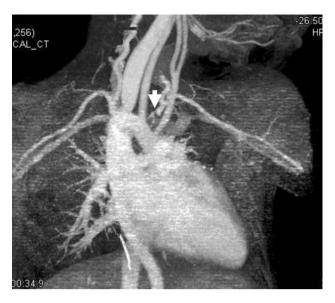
Preoperative three-dimensional computed tomography angiogram showing the right aortic arch with an isolated left subclavian artery (arrow)
